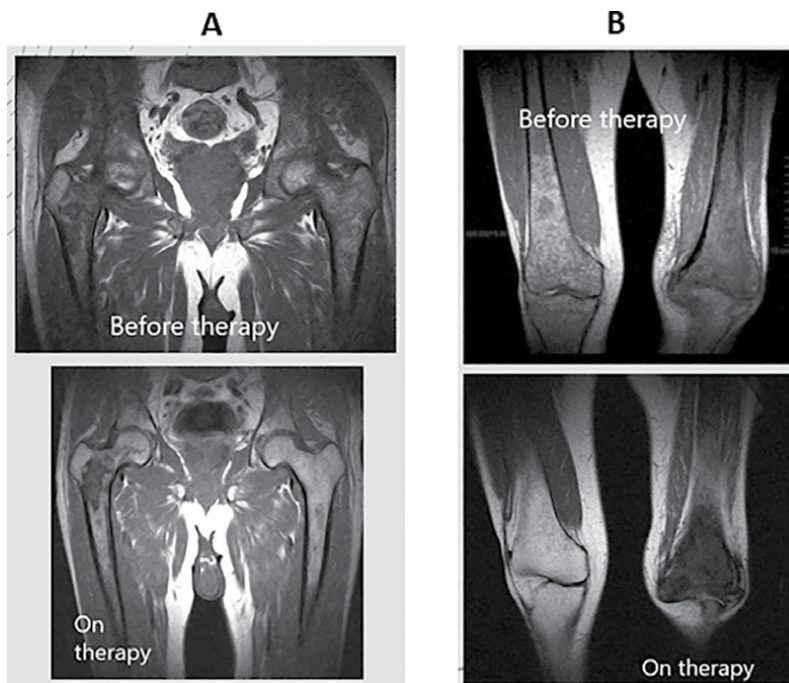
Coronal spin echo (SE) T1 (A) pelvis and femurs nonhomogeneous mottled pattern with infarcts in Gaucher disease before and after therapy. The therapy causes a decrease in intramedullary lipid storage with clearance and recovery of the physiological signal. Nevertheless, complications such as infarcts or necrosis are irreversible and more visible in MRI once the infiltration has been cleared. (B) Coronal spin echo (SE) T1 femurs and tibias nonhomogeneous mottled pattern with large infarct-necrosis in Gaucher disease before and after therapy.
